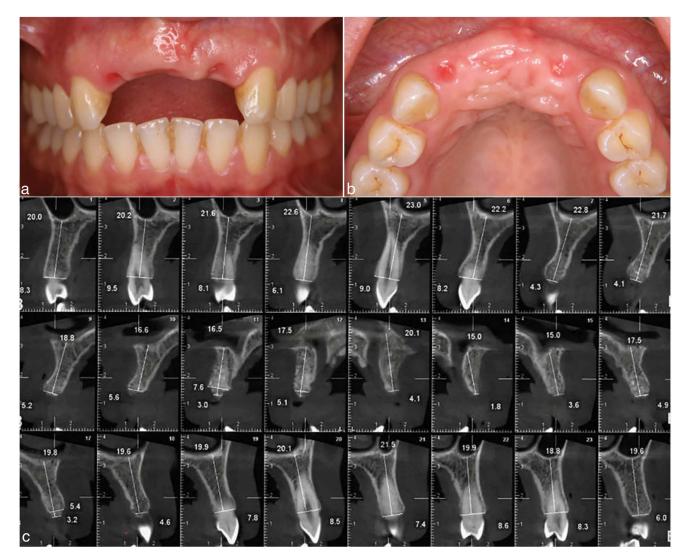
Preoperative clinical photographs of one of the subjects indicate missing 4 anterior teeth. (a) Frontal view. (b) Occlusal view. (c) Baseline cone-beam computerized tomographic images. Note the 3-dimensional loss of alveolar ridge in the anterior maxilla.
